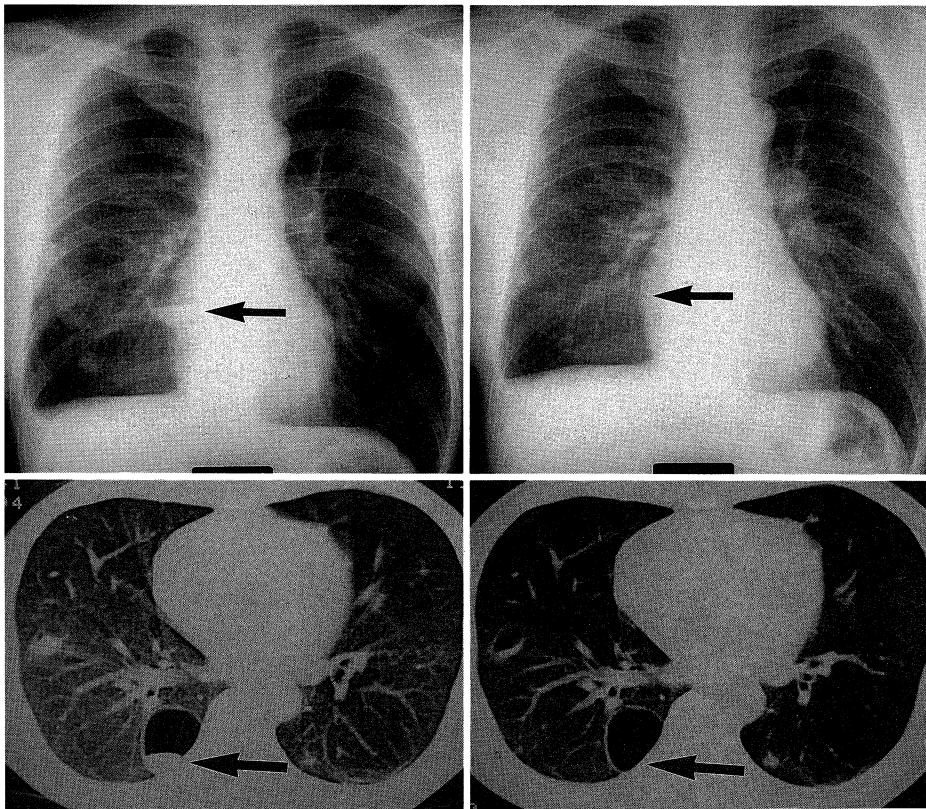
Chest X-ray films of Case 1 by frontal view (upper) and CT films (lower) before (left side) and after (right side) treatment
